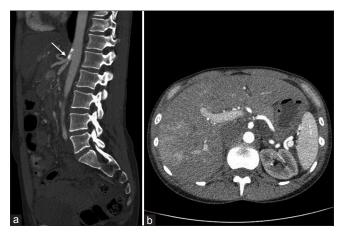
Patent splanchnic arteries (arrow) on computed tomography angiography (sagittal plane) (a) and hyperperfusion state of liver and spleen as evinced by strong portal venous enhancement in this arterial phase scan (axial plane) (b)
